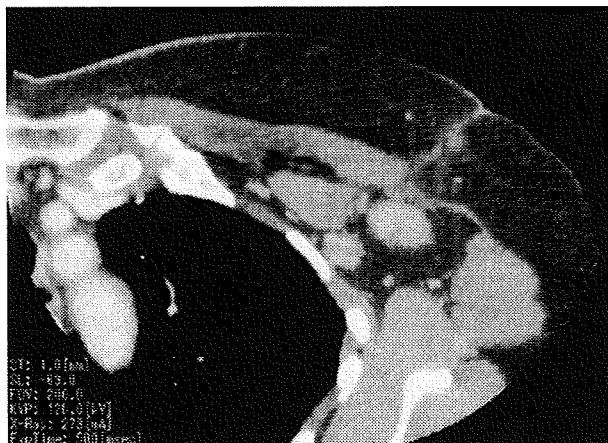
Contrast-enhanced CT showed several enlarged lymph nodes with a maximum size of 3 cm at Levels I and II
